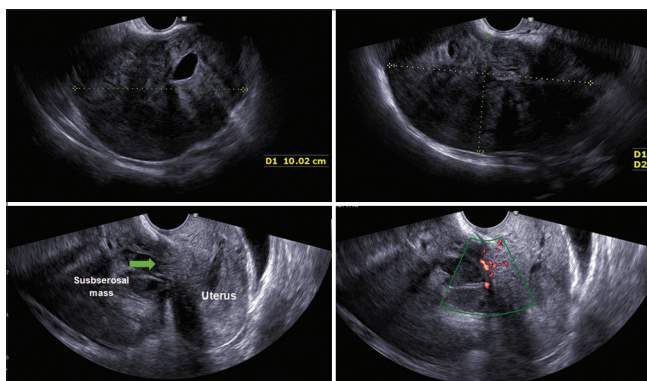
Transvaginal ultrasound findings. (Left to right, upper row) anteroposterior view of the posterior myometrium. Transverse view of the posterior myometrium. (Left to right, lower row) pedicle (arrow) of the subserosal uterine mass attached to the posterior isthmus area of the uterus. Color flow mapping of the pedicle showing minimal vascularity (color score = 1)
